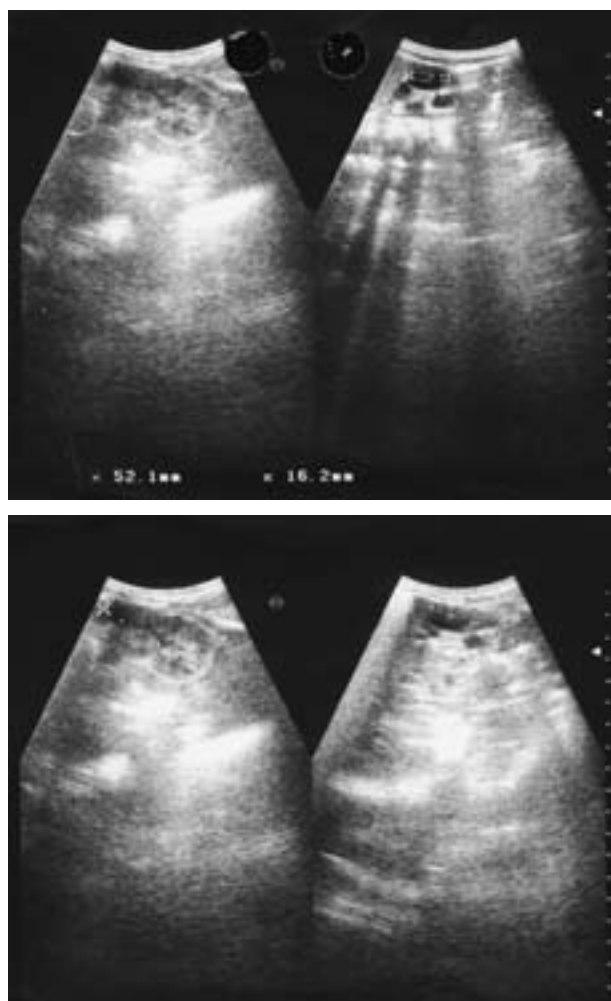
Ultrasonography of the kidneys demonstrated an enlarged right kidney containing multiple noncommunicating cysts.
